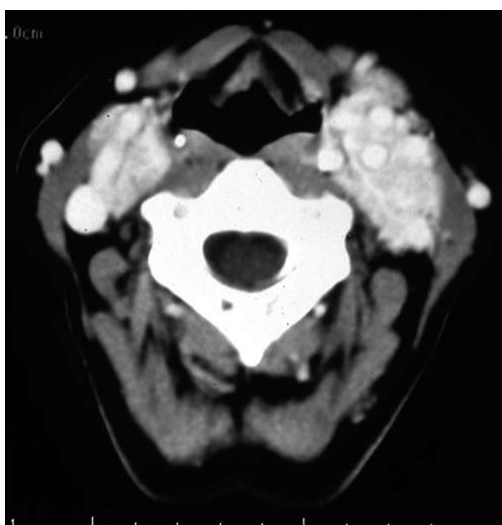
Contrast-enhanced CT scan of neck showing, on left side, a mass 6.4 x 2 cm. On right side: another mass 31.5 x 15.5 mm at level of carotid bifurcation reliable to the carotid body tumour removed in another hospital.
